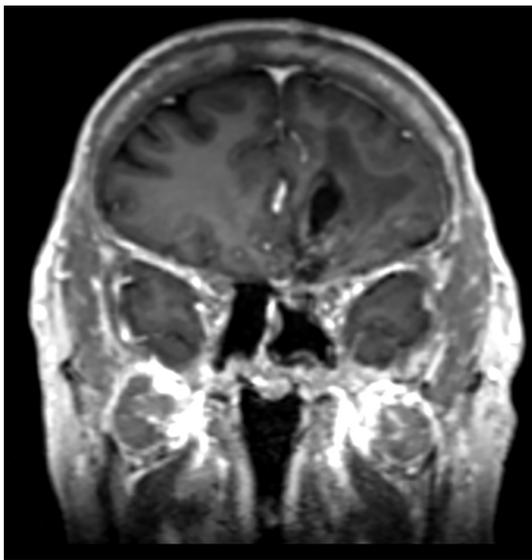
A coronal T1 contrast MRI displaying gross total resection.
